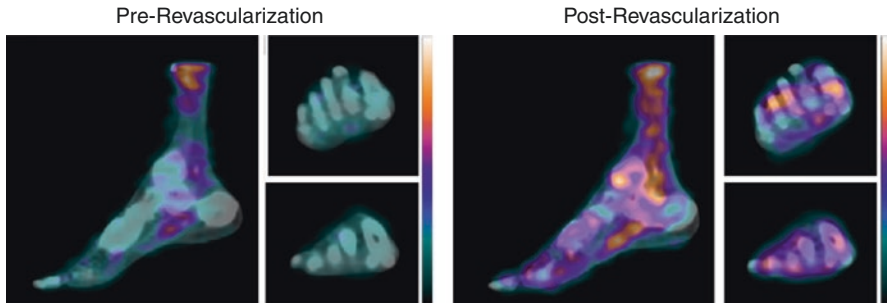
A diabetic patient underwent single-photon emission computed tomography (SPECT)/CT perfusion imaging of the feet before and after revascularization. CT images were segmented into angiosomes and relative radiotracer uptake was quantified
